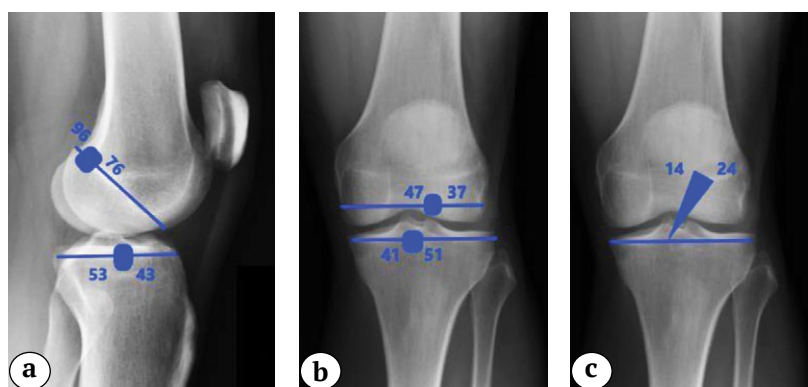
Plain X-rays of the knee joint showing anatomical tunnel parameters and GIA:
